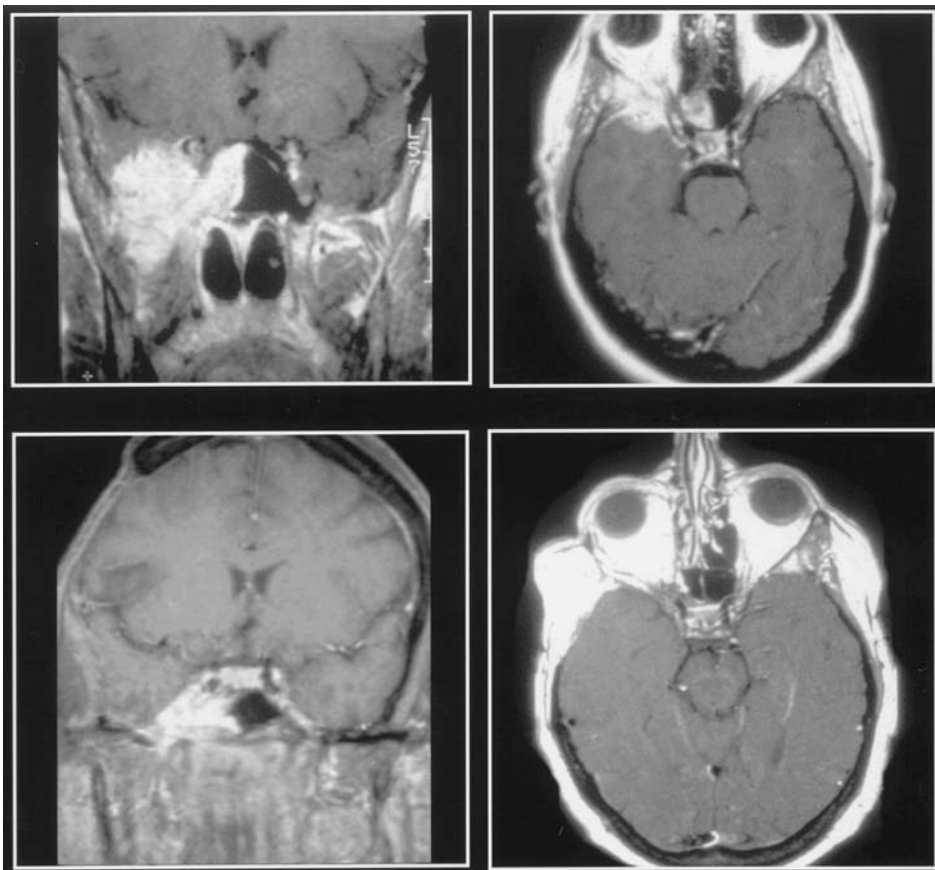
Coronal and axial gadolinium-enhanced T1-weighted MR images obtained in a 47-year-old female patient presenting with a 3-year history of right-sided V2 numbness and mild proptosis (left upper and right upper). This large orbitosphenoid meningioma also extends into the infratemporal fossa and the nasal sinuses. Aggressive subtotal resection was achieved, with the residual tumor in the nasal sinuses only (left lower and right lower).
